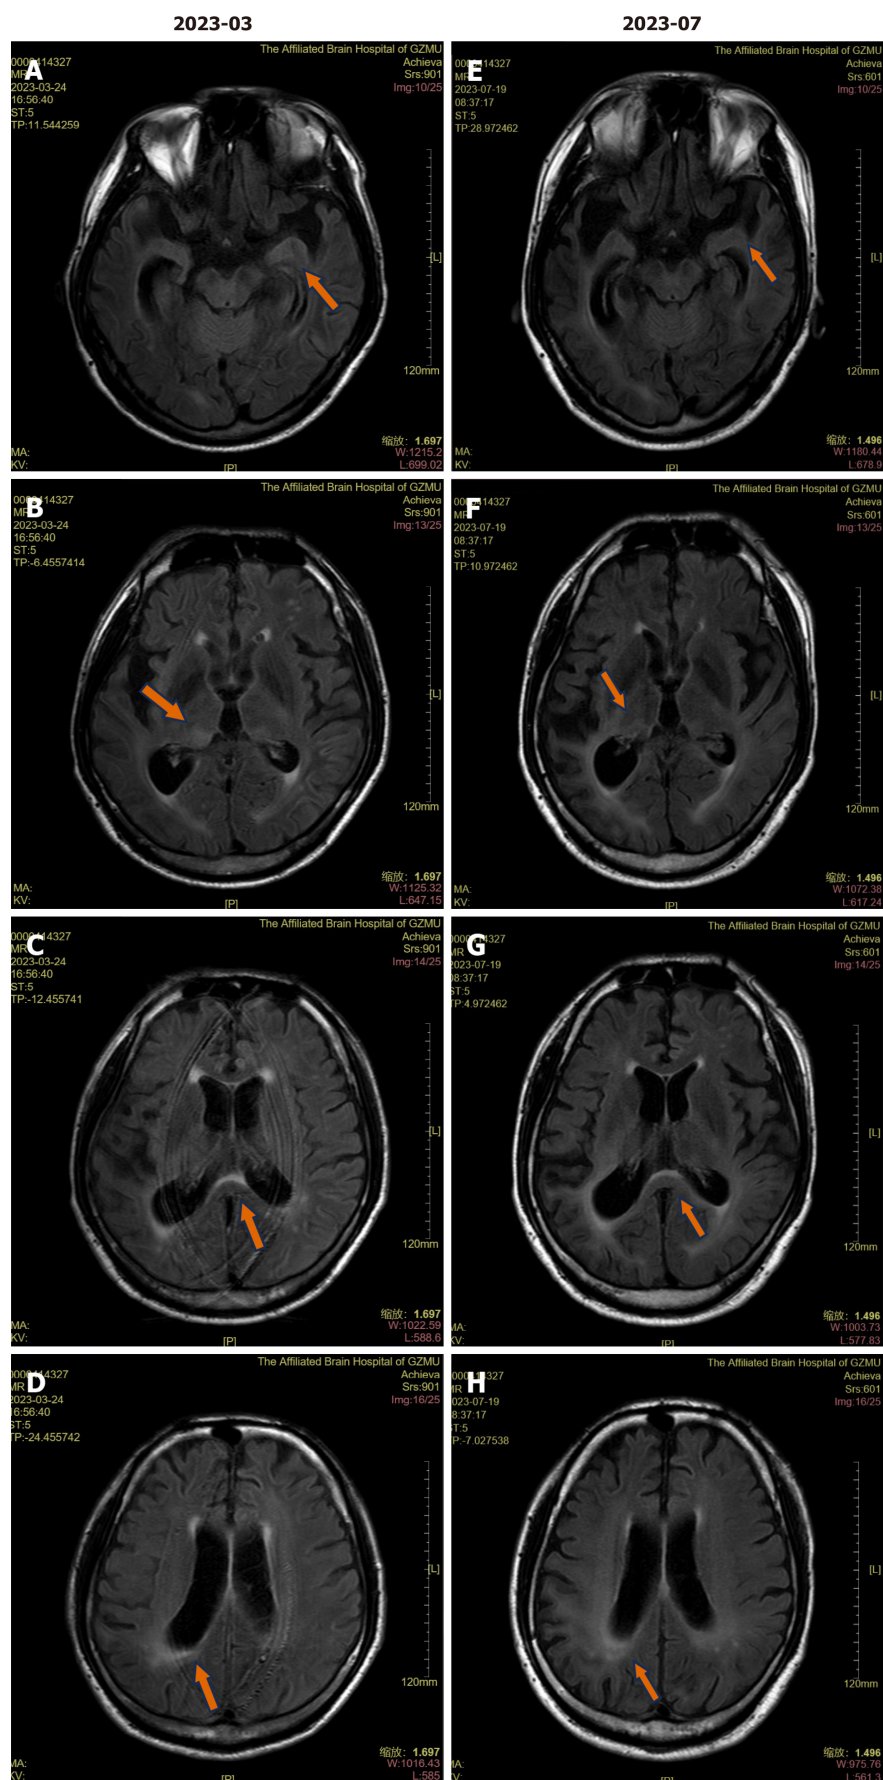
Brain magnetic resonance imaging scan on admission and after three months. A and E: T2 fluid-attenuated inversion recovery (FLAIR) image shows the high signal of the left amygdala; B and F: T2 FLAIR image shows the high signal of the right thalamus; C and G: T2 FLAIR image shows the high signal of the corpus callosum; D and H: T2 FLAIR image shows the high signal in the white matter surrounding the posterior part of the lateral ventricular body.
